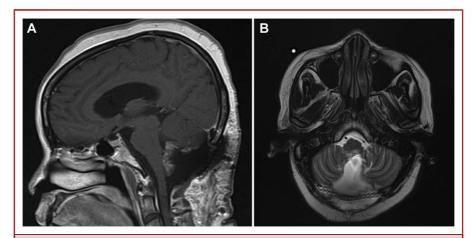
Postoperative MRI revealing near-complete resection of the tumor with expected residual along the posterior pontomedullary junction in A, sagittal and B, axial planes.
